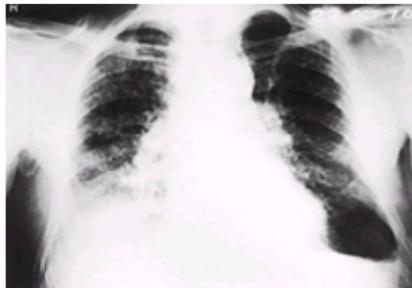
Chest radiograph of a worker with simple silicosis. Note the evidence of a resolved pleural effusion in the right hemithorax.
